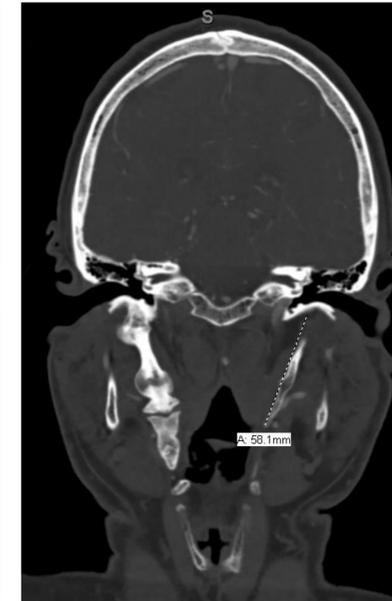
Left styloid process on CT imaging at initial presentation
